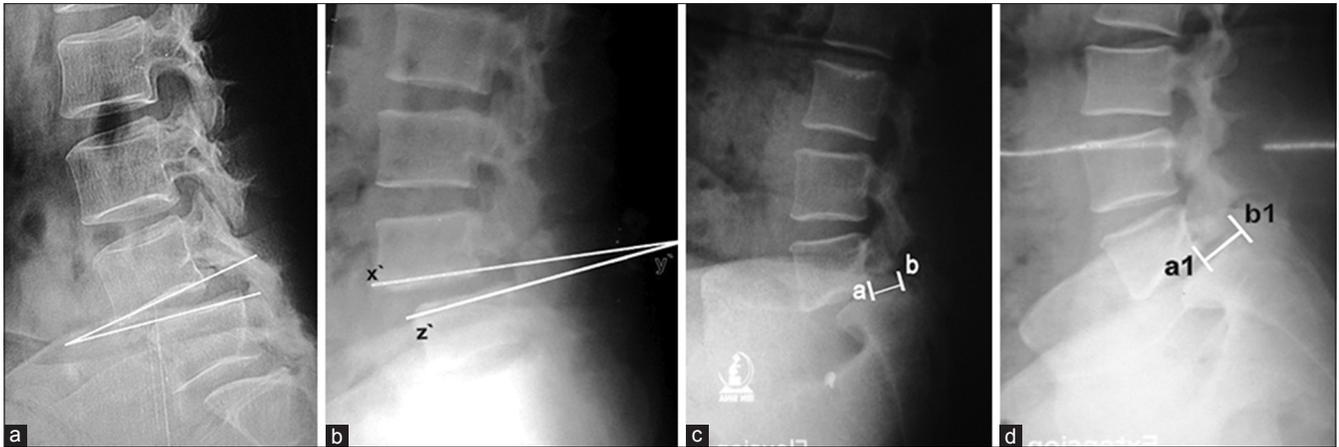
X-ray lumbosacral spine lateral view showing (a) Measurement of instability according to posner;³ Dynamic lateral film (flexion) in standing posture showing $>10^\circ$ sagittal rotation (angular displacement); measurement is done by the angle formed between the two adjacent end-plates. (b) Dynamic film in extension. (c) The dynamic films producing anterior translation measured as the distance between a and $b = d$ (in flexion). (d) The distance of a_1 and $b_1 = d_1$ (in extension). The distance difference (D) in flexion (d) and extension (d_1) calculated as the percentage ($D = d - d_1$ above vertebral width $\times 100$) of the width of the above vertebra
